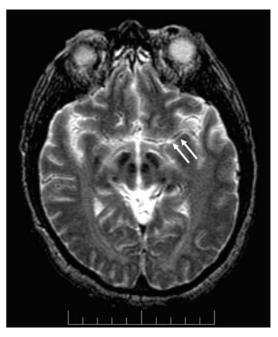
This axial, fluid-attenuated inversion recovery (FLAIR) image (TR 11,002 ms, TE 217 ms, TI 2,200 ms) shows hyperintense signal around the middle cerebral artery in the left Sylvian fissure (*arrows*)
